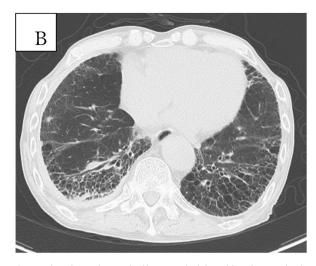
Chest computed tomography revealing the resolution of infiltrates at the bilateral lung bases and a decrease in bilateral pleural effusion.
